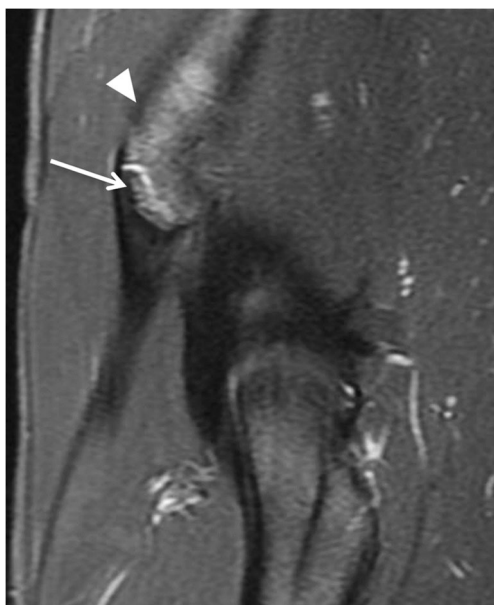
15-year-old male, professional soccer athlete with anterior inferior iliac spine apophysitis. Sagittal T2-weighted fat-suppressed MRI of the hip shows apophysis (arrow) and subapophyseal bone marrow edema (arrowhead) of the AIIS, with no displacement of the apophysis
